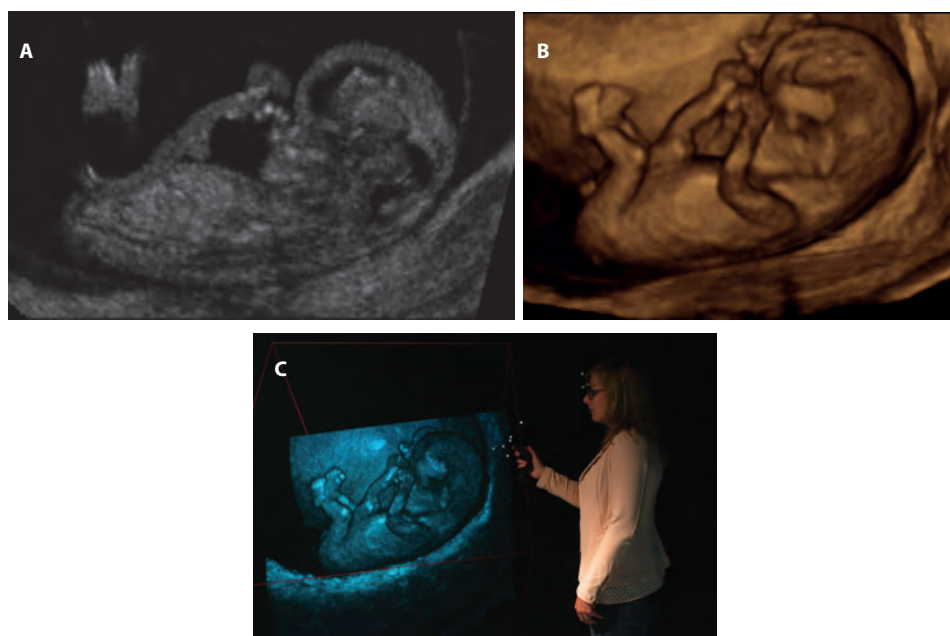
A fetus of 10+3 weeks' gestational age is visualized in (A) two-dimensional ultrasound, (B) three-dimensional ultrasound (3D) and (C) the Barco I-Space 3D virtual reality system. The viewer is wearing polarized glasses and is holding the wireless joystick, both equipped with a tracking system. Please note that this two-dimensional picture cannot express the three-dimensionality of the original 'hologram'.
